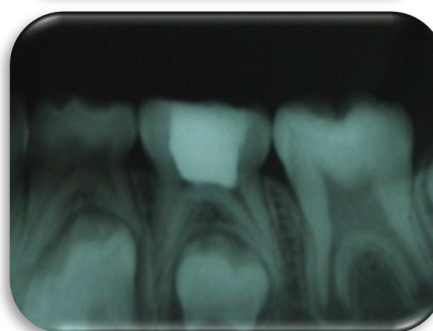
6th month follow-up clinical picture and radiographic picture
